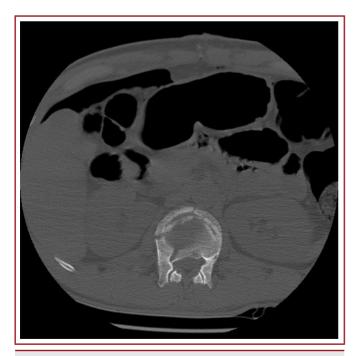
Preoperative thoracal fracture axial CT image
